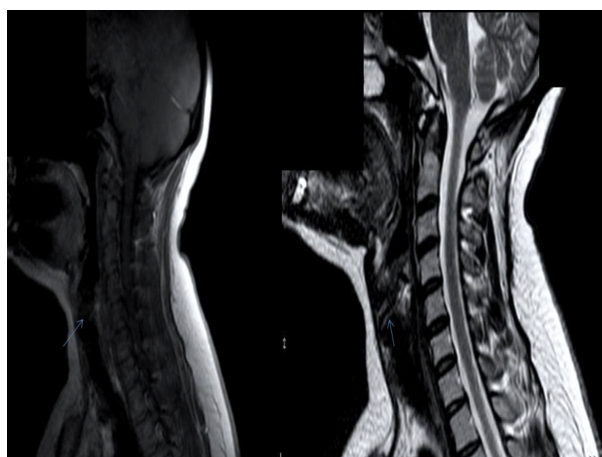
MRI highlighting of false vocal cords (left) and true vocal cords (right).
